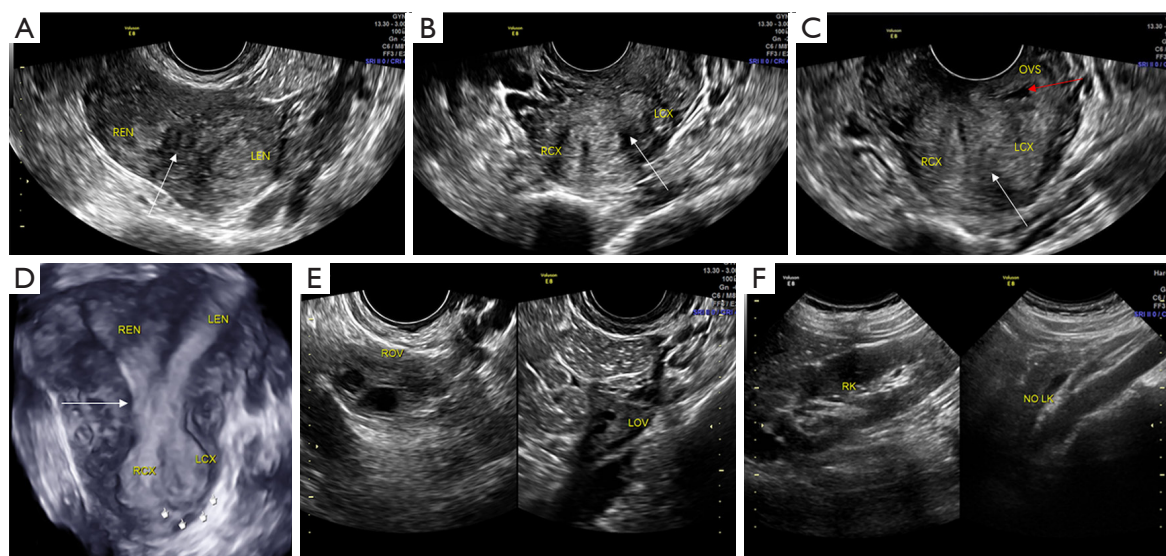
Type I-c UGTOIRA syndrome: U2a-C1-high OVS, partial septate uterus, septate cervix, with left-high OVS, with communication between the left and right lower part of the uterine cavity, and left renal agenesis. Sonograms were obtained from a 24-year-old female patient. (A) TVS 2D uterine cross plane demonstrating a partial septate uterus (the arrow indicates the uterine septate). (B) TVS 2D cross-section of the cervix demonstrating the cervical septate (the arrow indicates the cervical septate). (C) TVS 2D coronal plane of the cervix demonstrating the cervical septate and left-high OVS with a small amount of hematocele in the posterior space of the OVS (the white arrow indicates the cervical septate; the red arrow indicates the hematocele). (D) TVS 3D coronal plane of the uterus-cervix-vagina under stereoscopy demonstrating the partial septate uterus and septal cervix with left-high OVS and a small amount of hematocele filled in the posterior space of the OVS (the arrow indicates the OVS). (E) TVS 2D ovarian sagittal planes demonstrating both normal ovaries. (F) TAS 2D sagittal planes identifying the absence of the left kidney (NO LK; right side of the figure) and a normal right kidney (RK; left side of the figure). REN, right endometrium; LEN, left endometrium; RCX, right cervix; LCX, left cervix; OVS, oblique vaginal septum; ROV, right ovary; LOV, left ovary; RK, right kidney; LK, left kidney; UGTOIRA, unilateral genital tract obstruction with ipsilateral renal anomaly; TVS, transvaginal sonography; TAS, transabdominal sonography; 2D, 2-dimensional; 3D, 3-dimensional.
